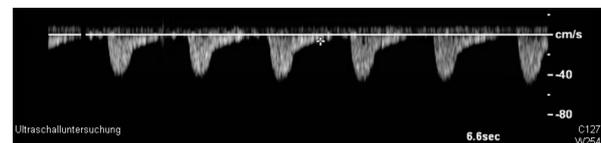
Doppler tracing on day 3 after biopsy. Note the increased duration of forward diastolic blood flow.
